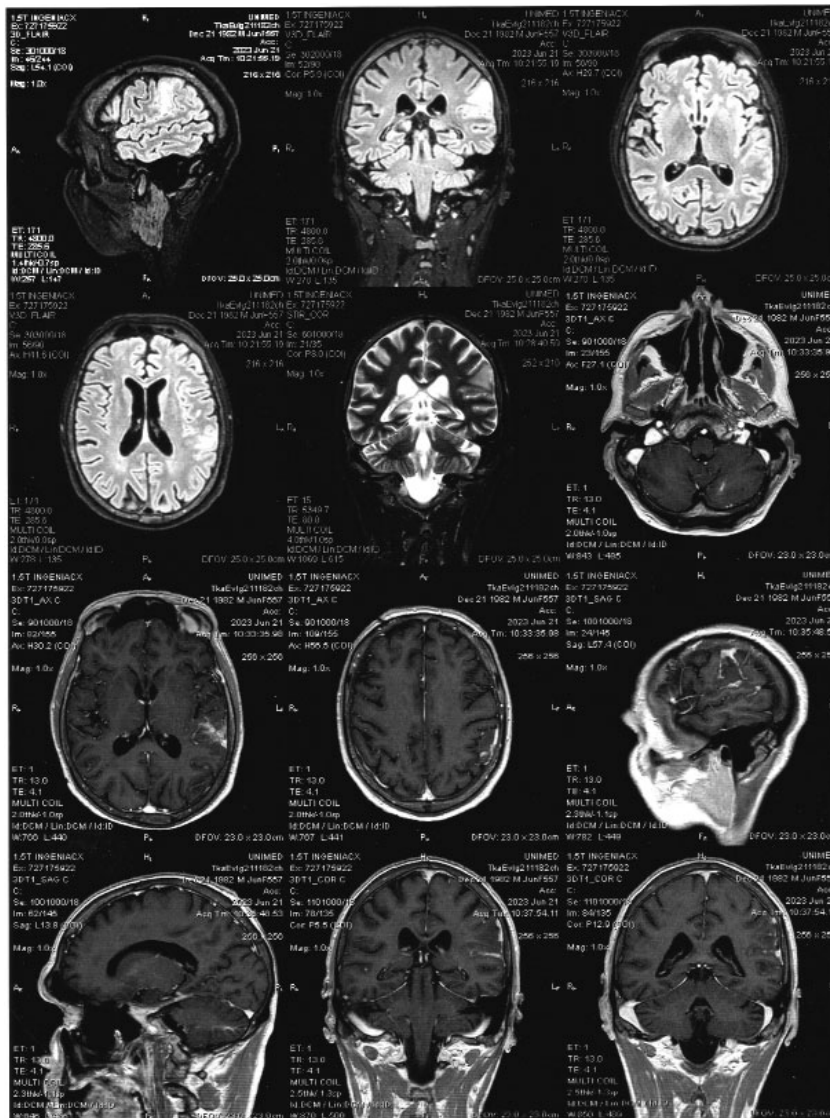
MRI of the brain from 21.06.2023
